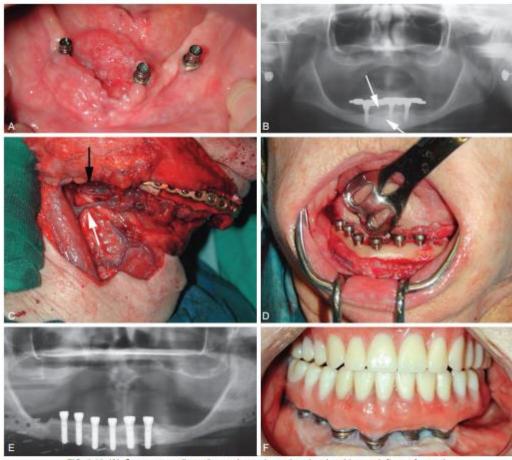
(A) Squamous cell carcinoma located on the alveolar ridge and floor of mouth. (B) Panoramic radiograph showing erosion of lesion into bone (arrows). (C) Intraoperative photograph after mandible and surrounding soft tissues were resected, and a free fibular bone flap and reconstruction bone plate have been used to reconstruct the mandible. Note the venous anastomosis (white arrow). The arterial supply to the flap is also shown (black arrow), but the actual anastomosis is located more proximally, under the tissue, and is not visible. (D) After the bone graft has healed, dental implants are inserted. (E) Panoramic radiograph showing the reconstructed mandible after implants have been inserted. (F) Intraoral view of prosthetic reconstruction of dental implants. The white tissue surrounding the implants is skin that was transferred with the bone flap. (Courtesy Dr. Remy Blanchaert, Jr. In Hupp JR, Tucker MR, Ellis E: Contemporary oral and maxillofacial surgery, ed 6, St. Louis, 2014, Mosby.)
